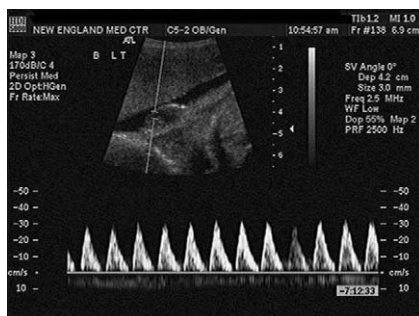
Color Doppler of umbilical artery showing absent end-diastolic flow.
